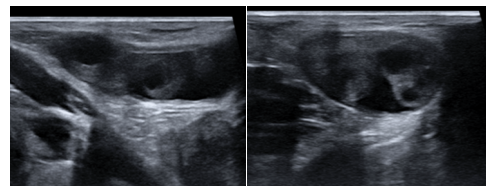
Ultrasound images showing bilateral ovaries in the hernia sac.
